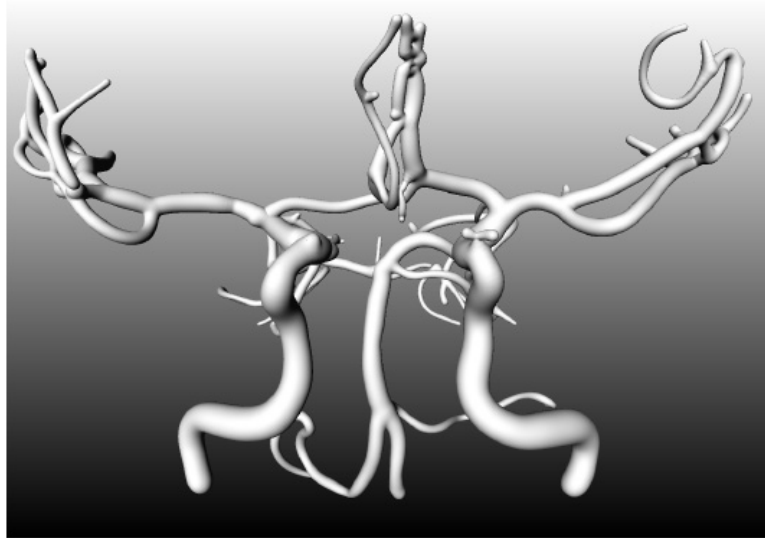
Visualization of cerebral vasculature imaged by MRI using a convolution surface [59]
